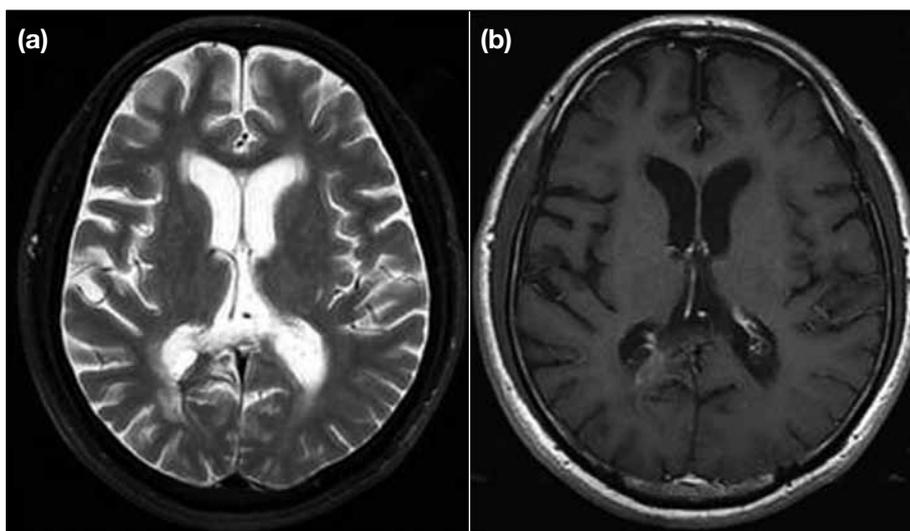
Magnetic resonance images after 2 years of antituberculous treatment. (a) T2-weighted and (b) postcontrast T1-weighted images show marked reduction in size and signal intensity, and near-complete resolution of the tuberculoma in the genu and splenium of the corpus callosum.
